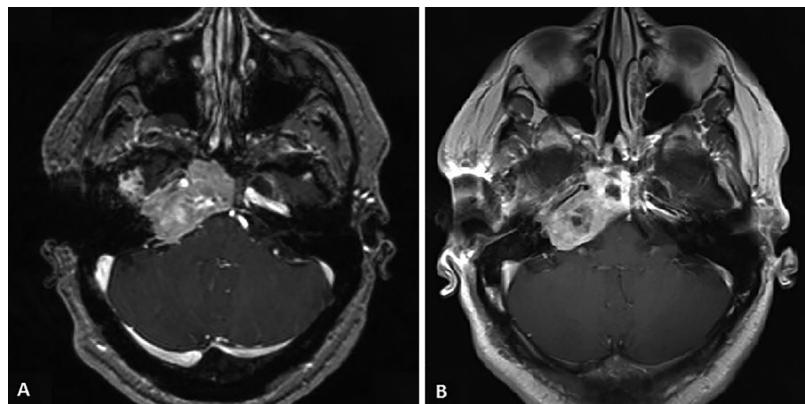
Magnetic resonance images before (A) and after (B) surgery of skull base tumour, showing a gross residual tumour with lower uptake in the central zone.
